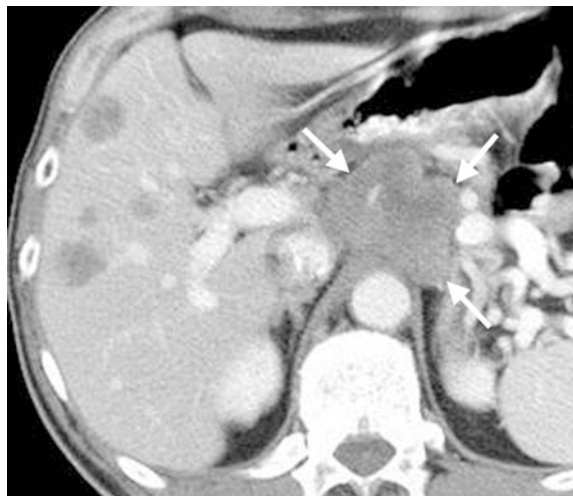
Liver and abdominal lymph node metastases: CT demonstrates multiple liver metastases and large bulky lymph node metastases between the stomach and abdominal aorta (arrows)
